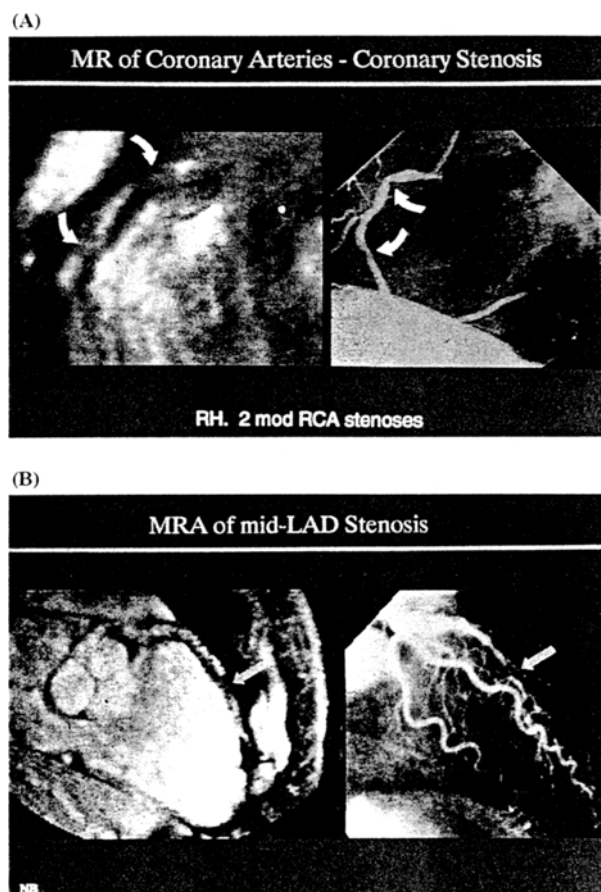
(A) This is a comparison between a magnetic resonance velocity encoded angiogram of the right coronary artery and a conventional X-ray angiogram. Although the image quality of the magnetic resonance image appears to be not as good as the angiogram the reality of the situation is that it contains far more diagnostic information. The velocity encoding enables assessment of the energy loss across the plaque and the pressure drop. (B) This is a similar comparison for the Left Anterior Descending coronary artery (LAD). The left coronary artery is more difficult to study than the right because it is more deeply placed lying behind the heart. The MR angiogram shown in (A) and (B) are cheaper to produce than the conventional angiograms and are produced without risk to the patient.
